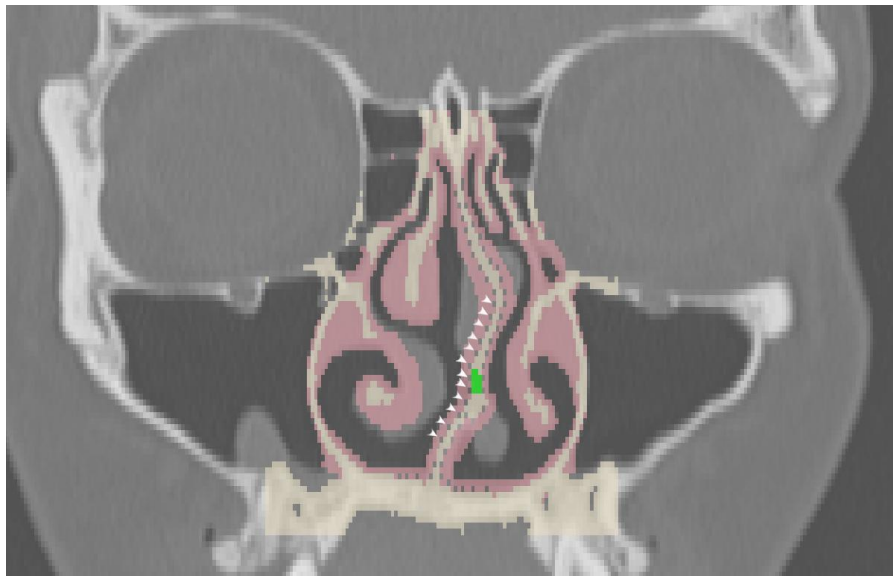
Coronal computed tomography view of the deviated nasal septum during the segmentation process. Arrowheads indicate the air bubbles added to the right side of the septum to reduce the adhesion between the mucosa and both bone and cartilage.
